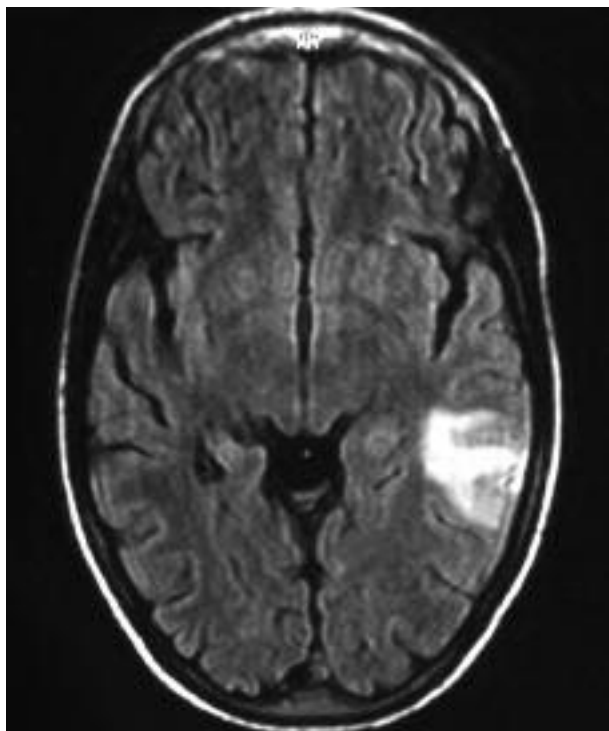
Cerebral magnetic resonance imaging (T2-weighted) showing one hyperintense left temporal lesion consistent with infarction.
